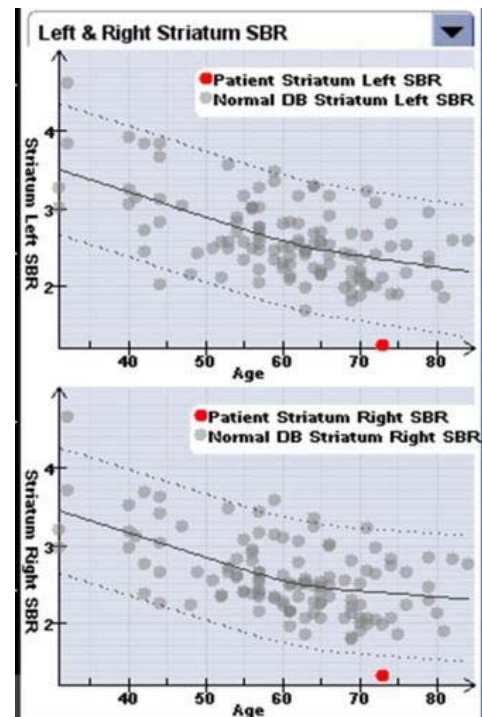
Graphs from a commercially available software (GE Healthcare) for the quantification of iodine-123 ioflupane SPECT shows the distribution of the striatal binding ratios for the left and right striata for healthy controls over a wide range of ages. The dashed lines indicate two standard deviations. This particular patient with PD (red dot) had severe loss of dopaminergic neurons in both striata that were worse than two standard deviations below age-adjusted normal.
